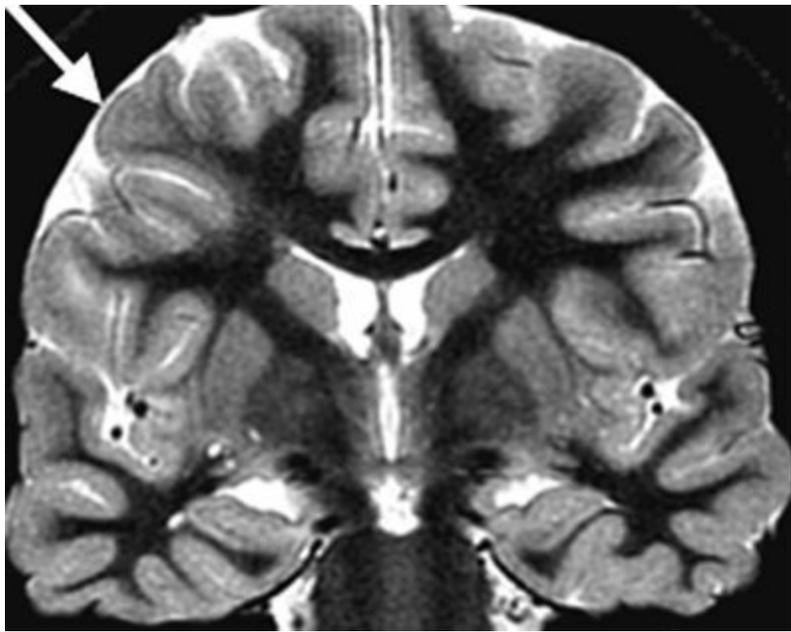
Coronal T2W MRI showing an area of irregular cortical folding (arrow) with blurring of the gray–white matter junction and underlying increased signal intensity in the white matter, extending from the subcortex to the ventricular wall. This combination of findings is consistent with FCD.
